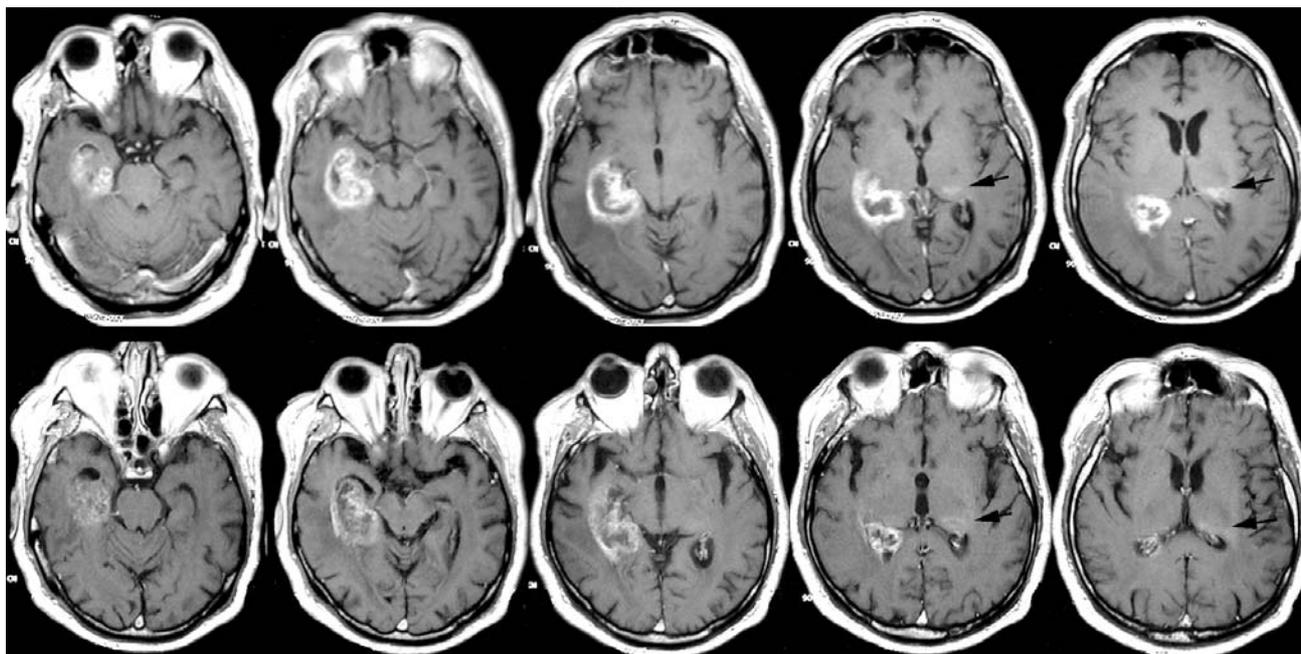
Gadolinium-enhanced MRI showed contrast enhancing diffuse glioblastoma in the right hippocampal region and the right lower temporal gyrus with perifocal edema and a second focus (arrows) on the left side (upper line). Tumor size, contrast enhancement and perifocal edema were markedly decreased about 7 weeks later (lower line). The second focus (arrows) has also decreased in size.
